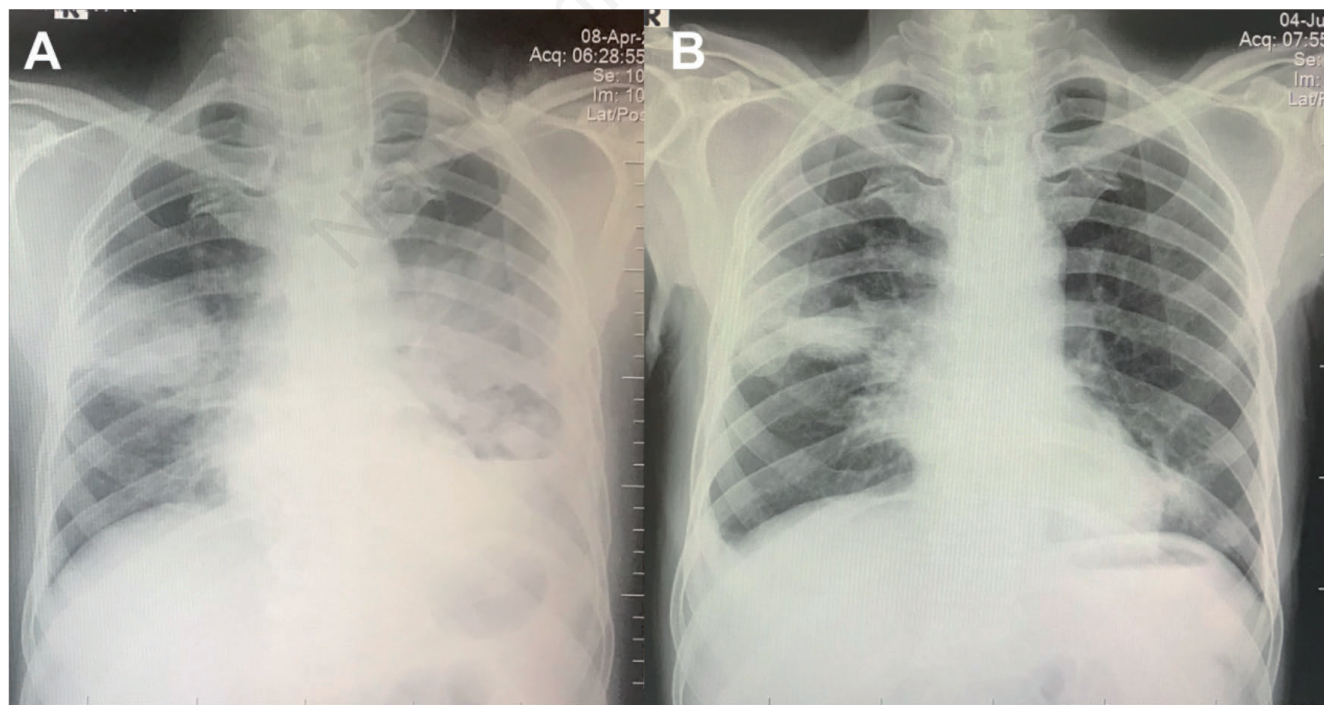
Chest radiograph. A) Right midzone and left mid and lower zone inhomogeneous opacities with blunting of left cardiophrenic angle. B) After 2.5g of LAMB, partial resolution with residual cavity in right midzone.
